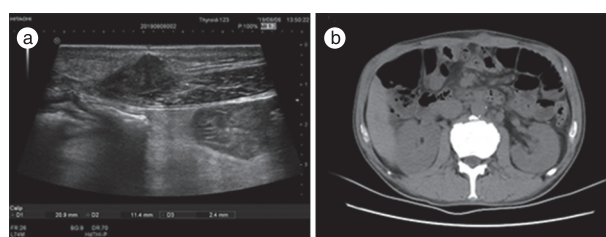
Ultrasound (a) and CT (b) showing a soft tissue tumor in the left upper abdominal wall
